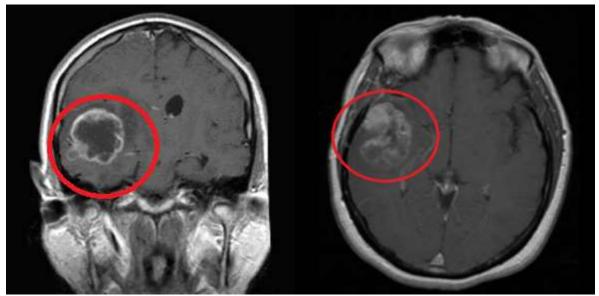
MRI - Peripheral enhancement after contrast injection in right temporal lobe tumor mass.
